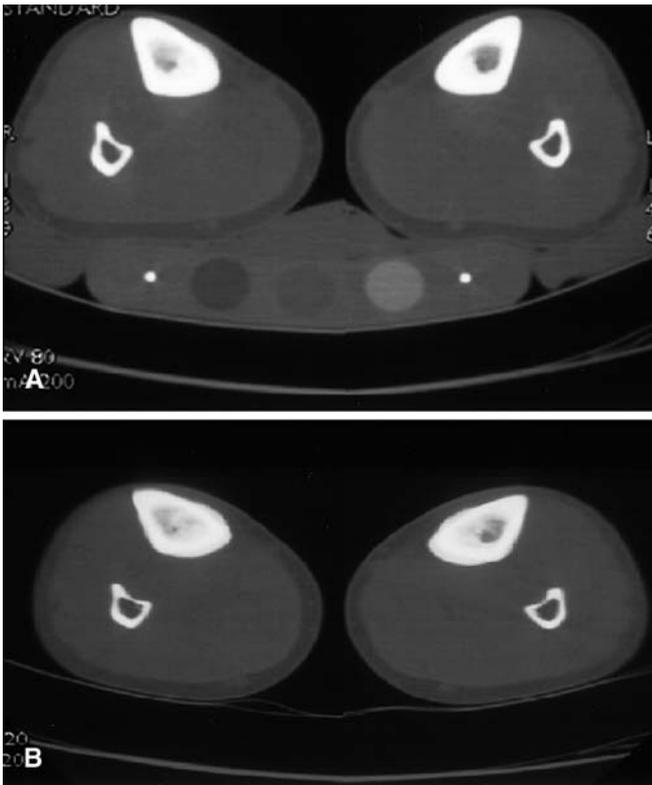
Pre- and post-treatment CT scan images of a patient with Ribbing disease. Axial images obtained before (A) and after (B) pamidronate treatment show thickening of the posterior medial cortices of both tibiae with marrow ablation that progressed with treatment
